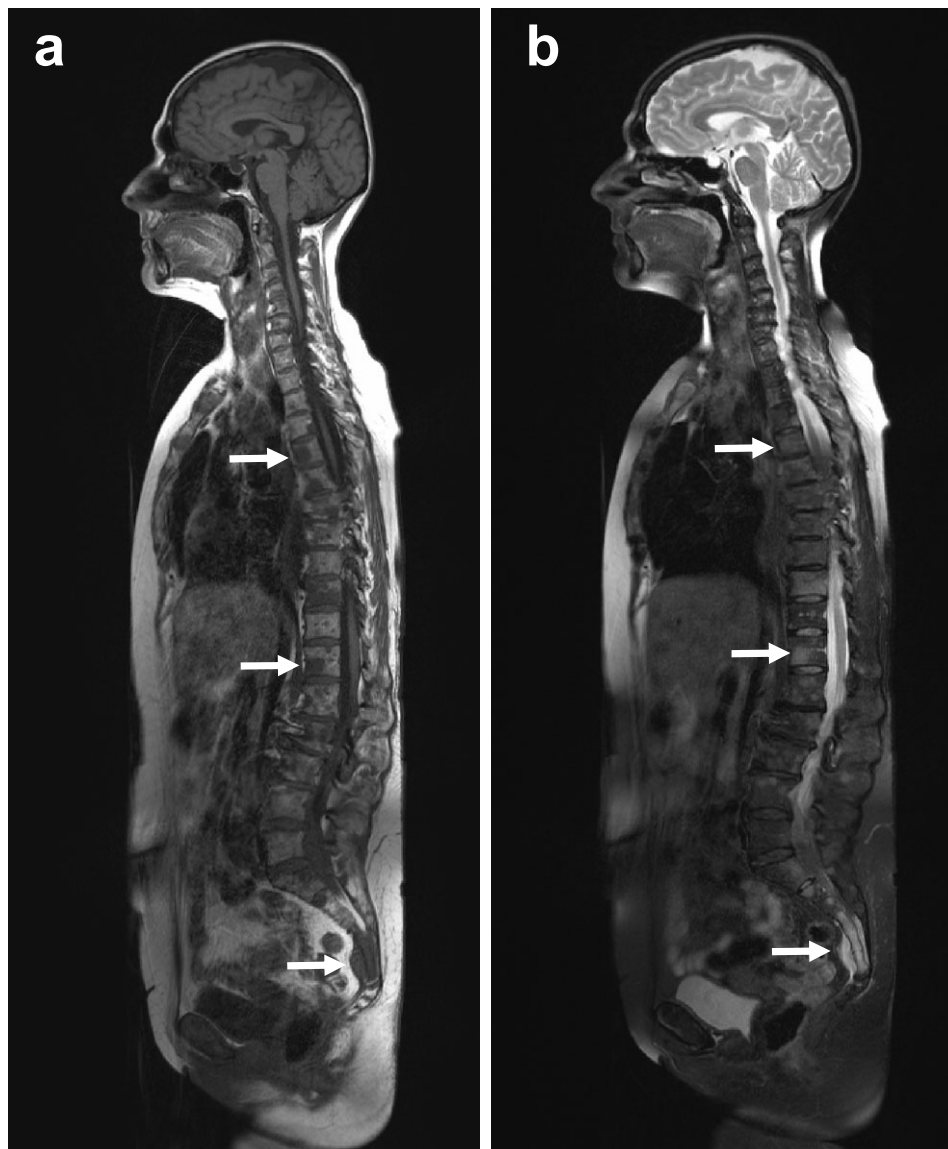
A 51-year-old patient with multiple myeloma in relapse. (a) T1-weighted spin echo (TR/TE 400/10 ms), (b) T2-weighted (TR/TE 3800/70 ms) fat-saturated turbo spin echo (echo train length = 21) sagittal images show multiple focal lesions within the bone marrow and a sacral mass (arrows). Lesions present with low signal on T1WI surrounded by high signal normal marrow and high signal on T2WI with fat saturation.
